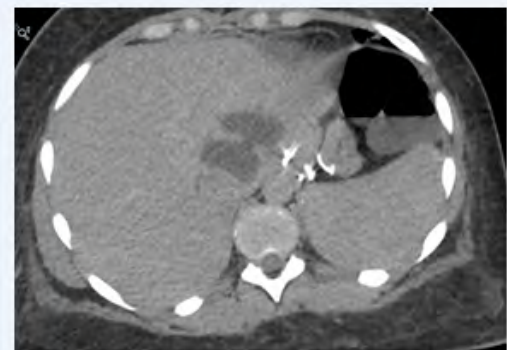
Triple phase CT scan of the abdomen and pelvis demonstrating two hepatic fluid collections with heterogenous rim, the largest measuring 5.1 by 4.6 cm in the left lobe.
